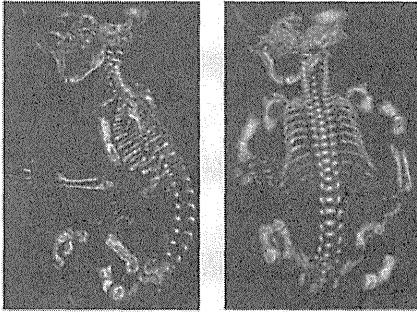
Three-dimensional computed tomography images show poorly mineralized craniofacial bones, curved limbs and short thick long bones with multiple fractures.
